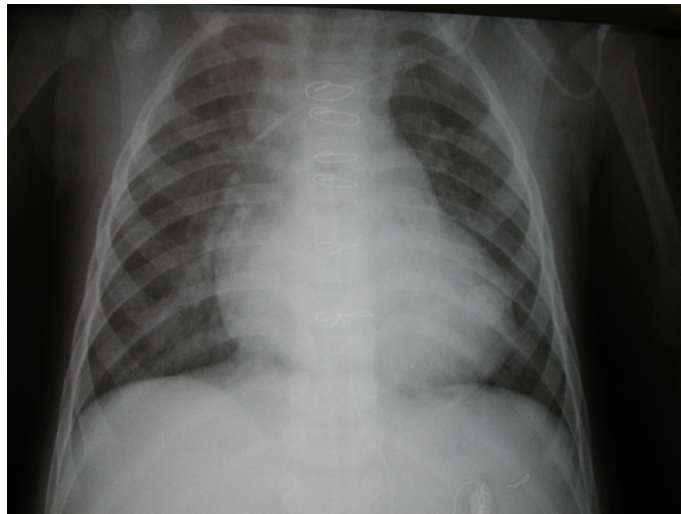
Radiographic image, six days after the surgical repair, still depicts the cardiomegaly, but without the upper dilations, after the thymus resection.
